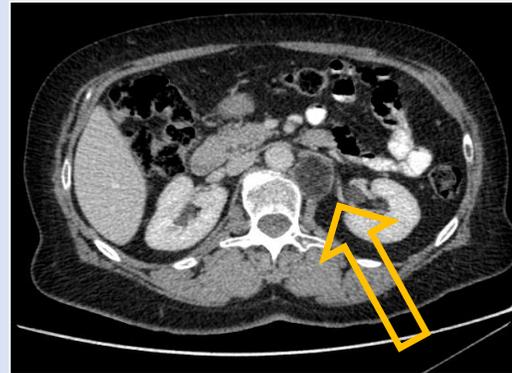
CT imaging of Retroperitoneal Soft Tissue Mass
